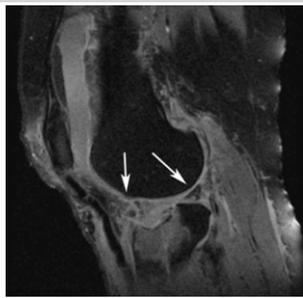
Sagittal T2-weighted MRI imaging reveals disruption of the anterior and posterior horns of lateral meniscus
